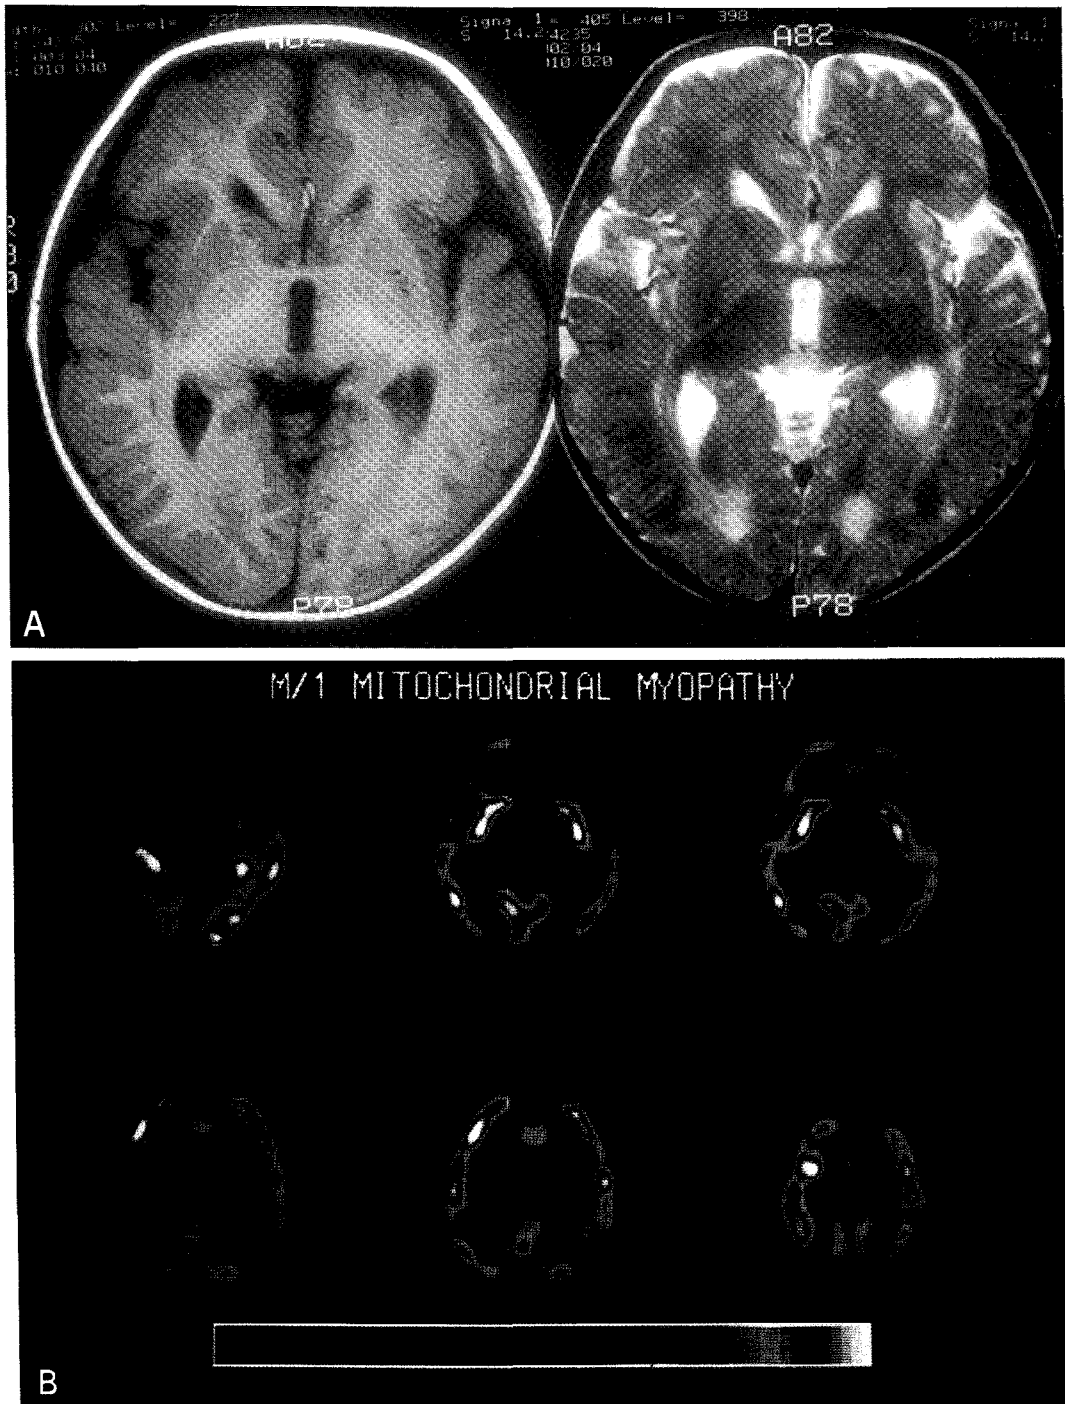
Case 3. 13 month-old male with mitochondrial myopathy who showed no clinical sign of encephalopathy. T1- and T2-weighted axial MR images (2A) showed no abnormal signal intensity or morphologic changes. Brain SPECT using Tc-99m ECD revealed (2B) decreased perfusion of left parietal cortex and bilateral thalami.
